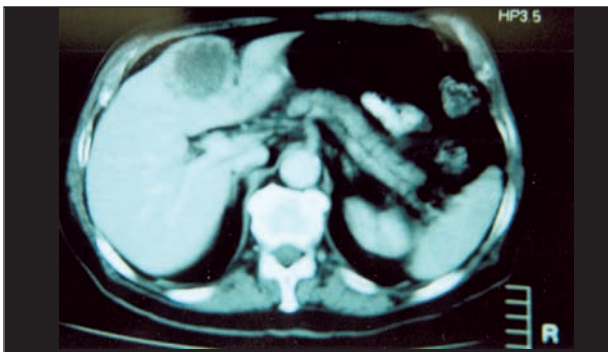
A. CT scan of abdomen shows metastatic disease of the liver.
